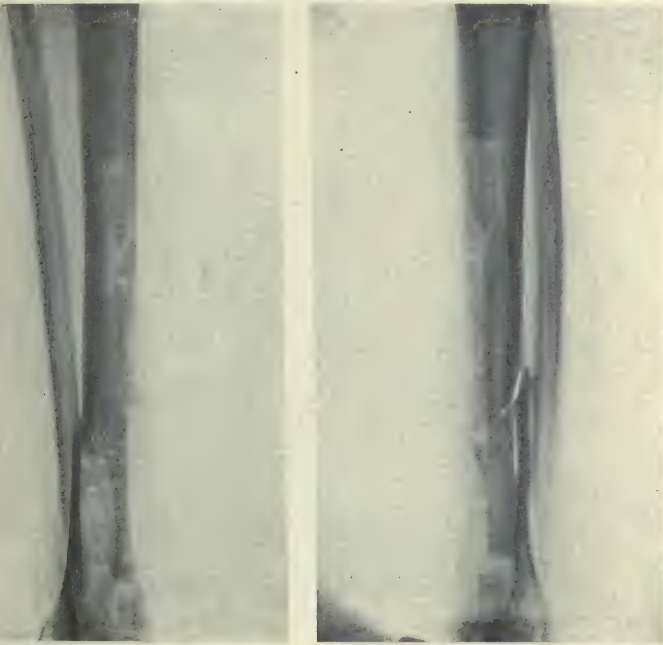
Oblique fracture of tibia, repaired by sliding inlay bone-graft. Good alignment of fragments; osteogenesis progressing favorably from graft and host bone. (X-ray six weeks after operation.) This patient had had three unsuccessful operations prior to the bone-graft; one included the insertion of a wire nail subcutaneously under the guide of fluoroscope. Although the author does not advocate the use of the graft as a routine measure in open operations, he believes that any case which has not been satisfactorily reduced in five to six weeks and exhibits no evidence of active callus formation at open operation at the end of that time, should be immobilized by an inlay graft, as was decided in this case.
